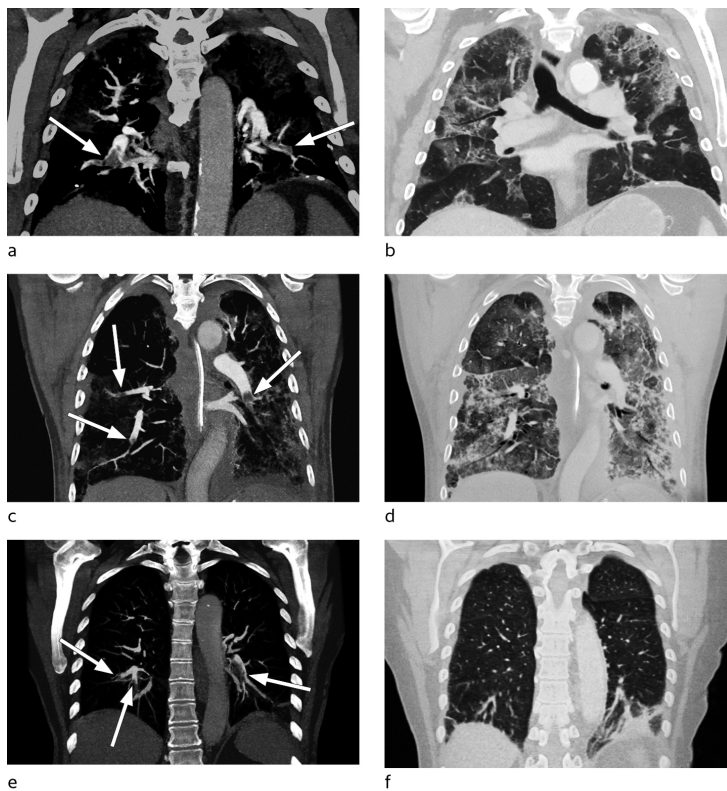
CT pulmonary angiography with coronal maximum intensity projection (MIP) reconstructions. The images show pulmonary embolisms in lower lobe pulmonary arteries in all three patients (a, c, e, arrows). Patients 1 (a, b) and 2 (c, d) also had bilateral opacities with features consistent with an infectious origin and a largely peripheral distribution that can be seen more clearly in the lung window (b, d). In patient 3 (e, f), a broad-based, rounded consolidation can be seen against the pleura at the base of the left lower lobe, most consistent with pulmonary infarction (f). Ground-glass opacities can be seen around the infarct, lungs are otherwise clear.
